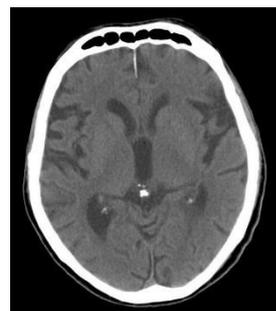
Patient – 59 years. Computed tomography image. Pineal calcification.
